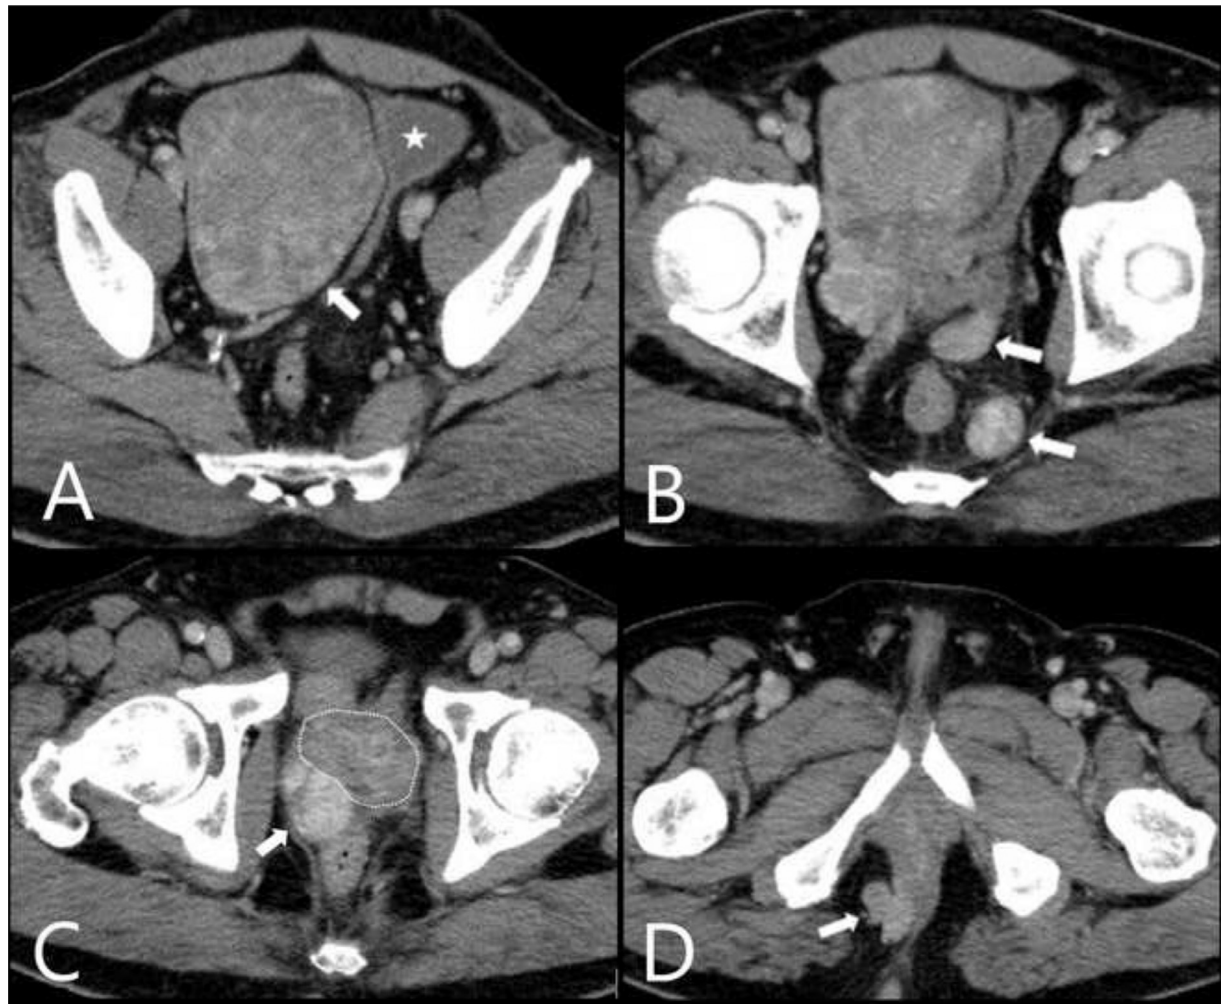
An axial contrast-enhanced CT (CECT) scan shows a heterogeneous contrast-enhanced mass (A, arrow) 14 cm in diameter on the right side of the urinary bladder (A, star). Other similarly small nodules are noted posterior to the seminal vesicle (B, anterior arrow), in the left sciatic region (B, posterior arrow), right posterolateral aspect of the prostate (C, arrow), and the perianal area (D, arrow).
